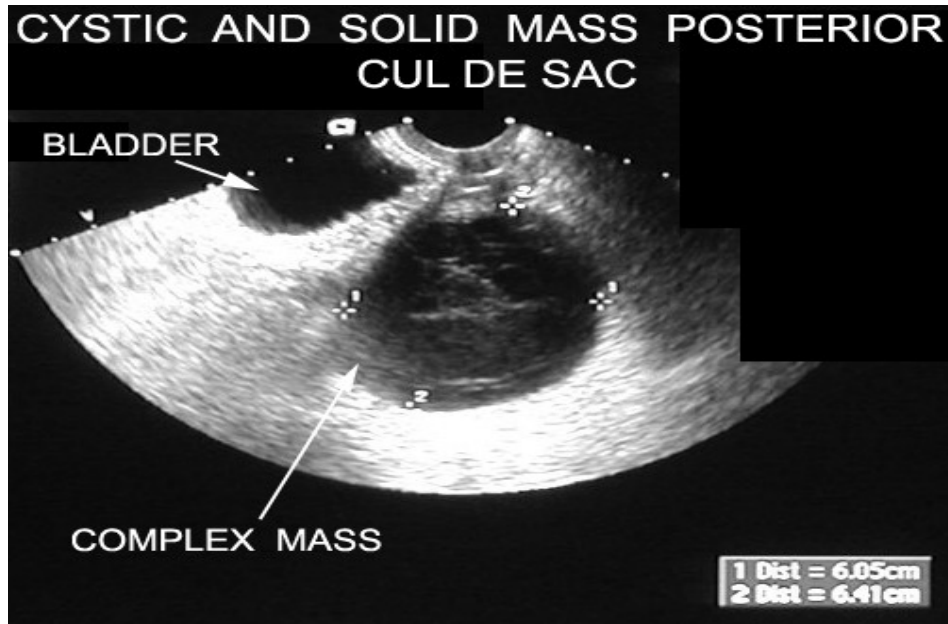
Complex cystic and solid mass - (www.ultrasoundimagegallery.com)
